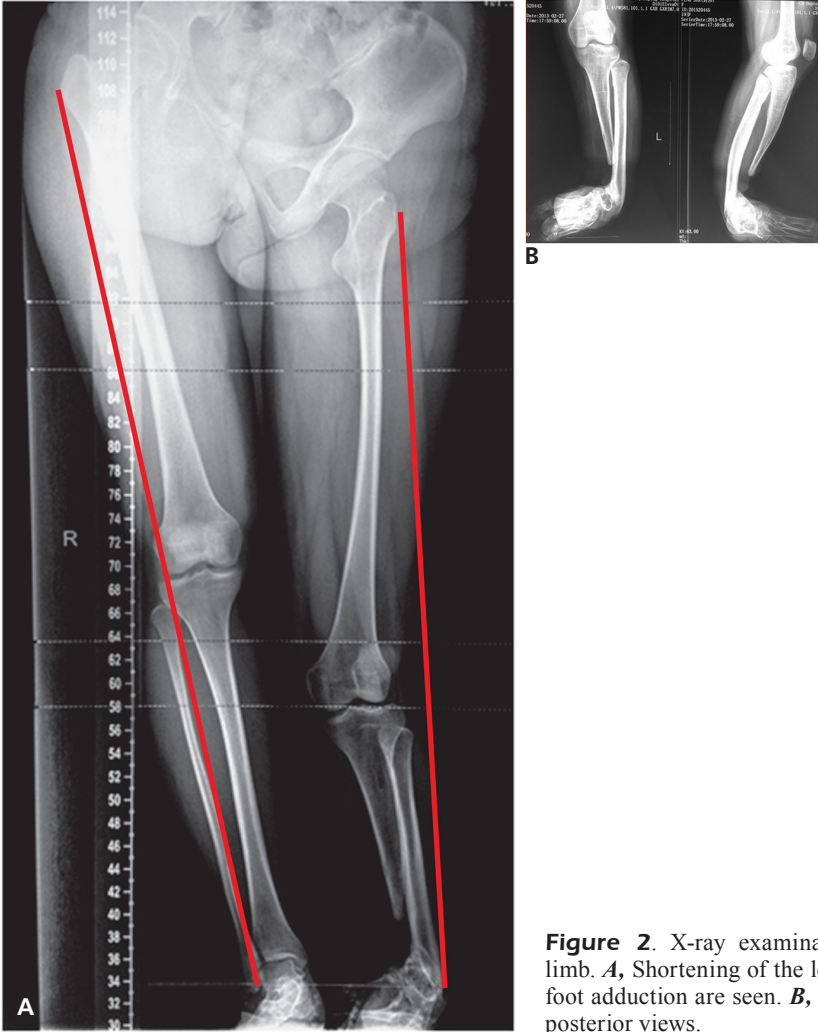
X-ray examination of the affected limb. *A*, Shortening of the left leg length and left foot adduction are seen. *B*, Left foot, frontal and posterior views.
